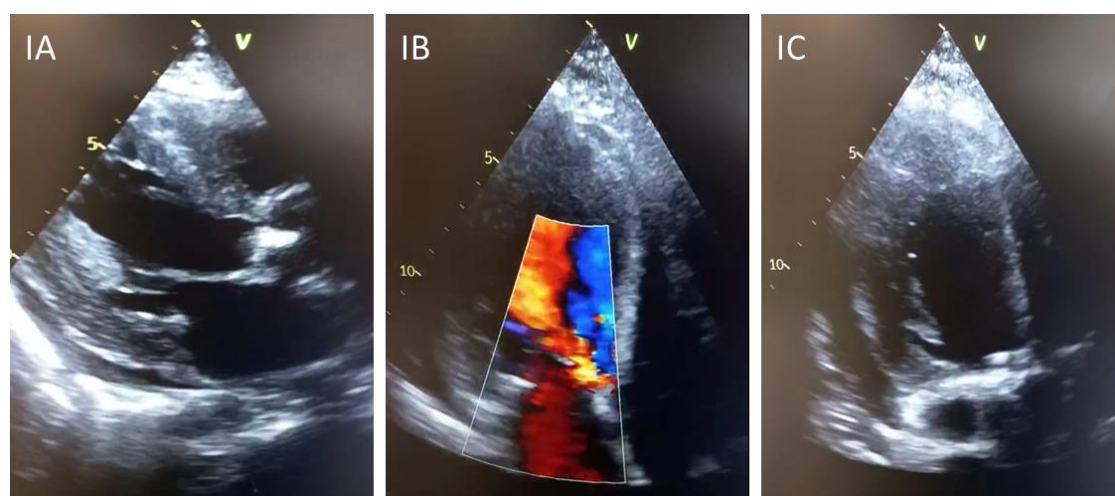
IA: Parasternal long axis showing thickened aortic valve cusps with dense hyperechoic structures protruding on both aortic and ventricular side of the valve. IB: 3-chamber view with Color Doppler showing severe aortic regurgitation. IC: 3-chamber long axis view showing dense hyperechoic mass on ventricular side of aortic valve.
